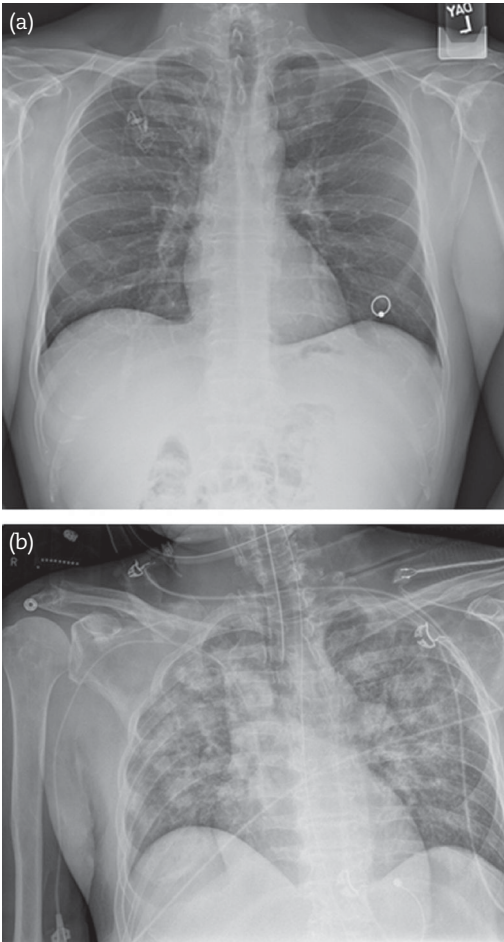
Chest radiograph shows diffuse bilateral infiltrates.
